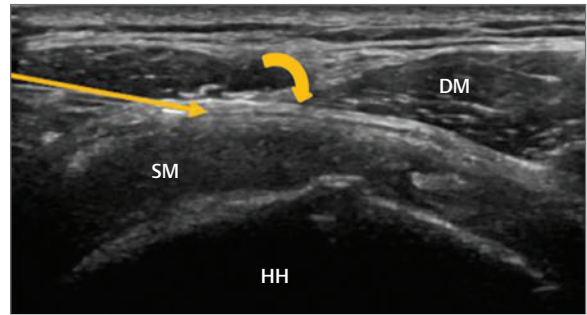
Ultrasound image of the anterolateral aspect of the shoulder. This is essentially a transverse image of the supraspinatus muscle (SM) which may be seen to cover the humeral head (HH). Overlying the supraspinatus muscle and deep to the deltoid muscle (DM) the subacromial bursa (*curved arrow*) may be seen as an echogenic line. The injection is given as a bolus and should flow freely with distension of the bursa noted. Straight arrow indicates the direction of the needle.
